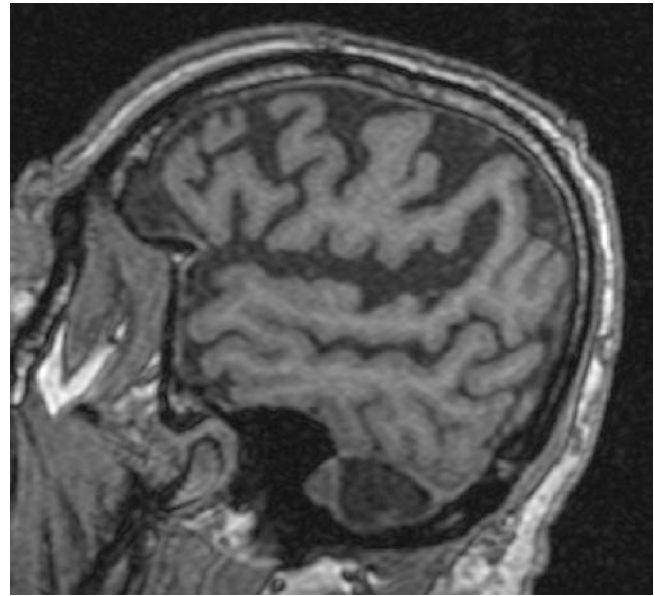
Alzheimer's disease. Sagittal MRI T1. Lateral parietal lobe and posterior temporal lobe (lateral parieto-temporal association cortex) atrophy. (Reproduced, with kind permission, from Dr. Lisa Tarlinton and courtesy of Nepean Hospital)
